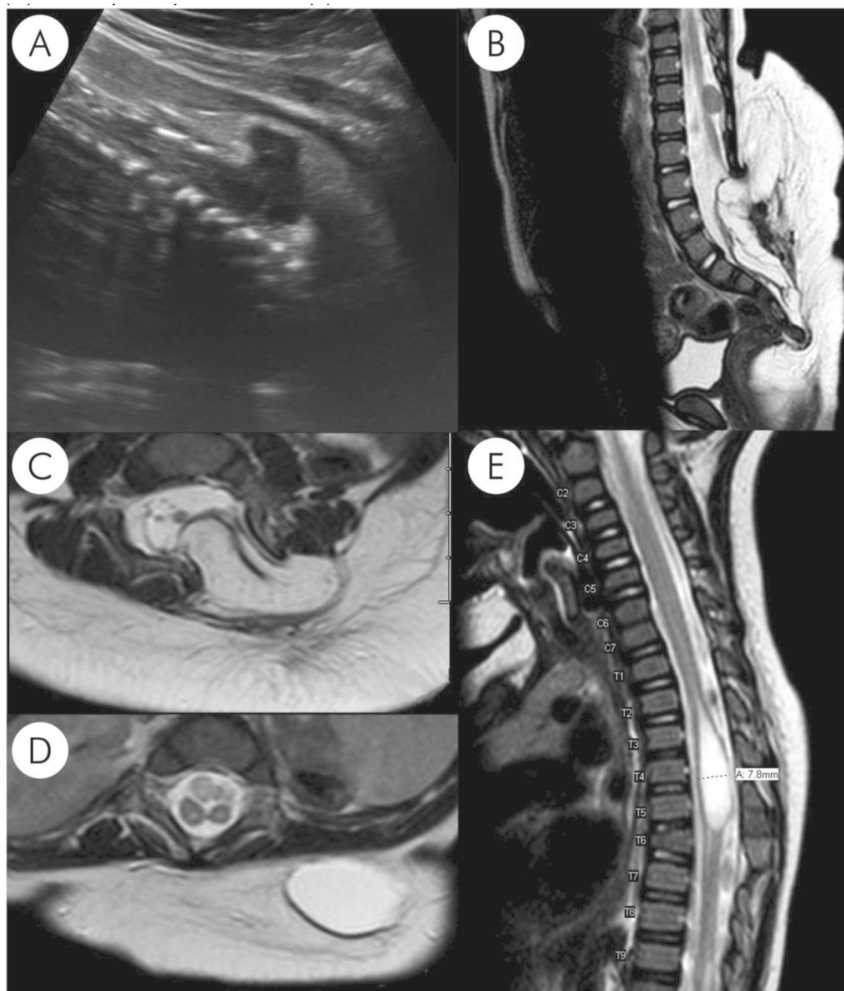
(A–E) Pre- and postnatal US and MRI of case 1: A: Prenatal US of the fetal spine at 22.4 weeks GA shows the spinal defect, positive continuous epidermis sign (B + C) postnatal T2-weighted sagittal and axial MRI image of the spine show a large and complex lumbosacral malformation with imaging features compatible with a lipomyelomeningocele. (D + E) postnatal T2-weighted sagittal MRI image of the spine show a diastematomyelia at Th12/L1 (D) and a hydromyelia at T2–T6 (E).
